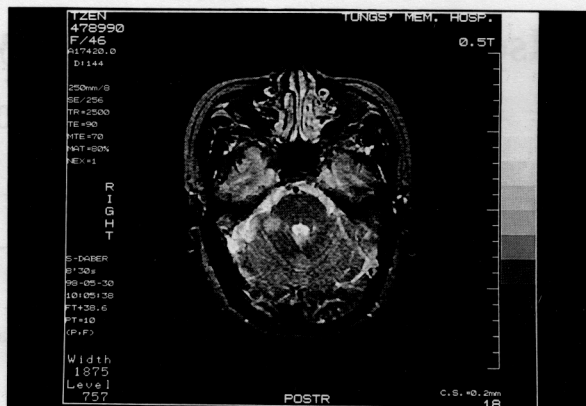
Axial view: T2-weighted image of MRI shows an infarction in the right middle cerebellar peduncle and flocculus.
